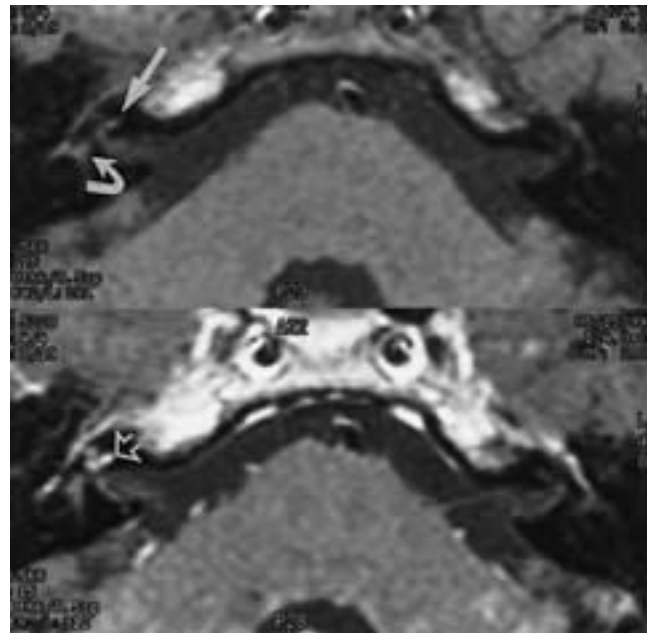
Labyrinthitis. T1-weighted images before (top) and after (bottom) gadolinium enhancement. Four weeks after trauma, this 21-year-old man had persistent hearing loss in the right ear. Note the mild hyperintensity of the right cochlea (arrow) and vestibule (curved arrow) on the unenhanced image. There is marked contrast enhancement of the cochlea (open arrow). There is normal bilateral enhancement of the tympanic segment of the facial nerve.
